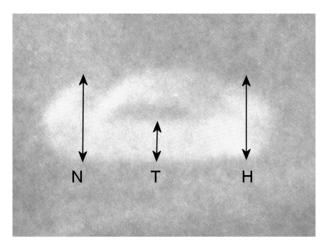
Typical X-ray image of Filshie clip showing key measurements.
